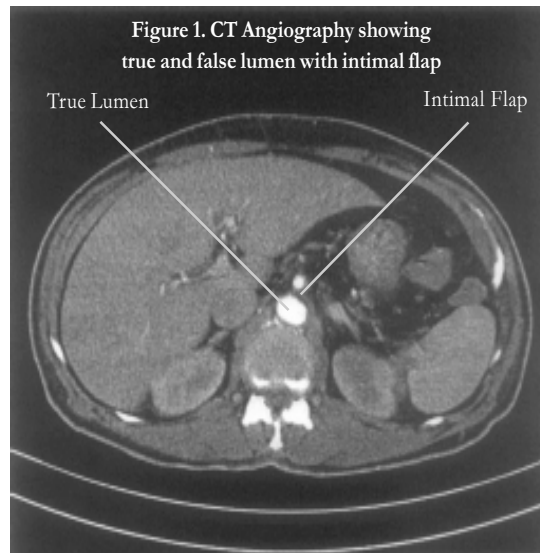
CT Angiography showing true and false lumen with intimal flap
